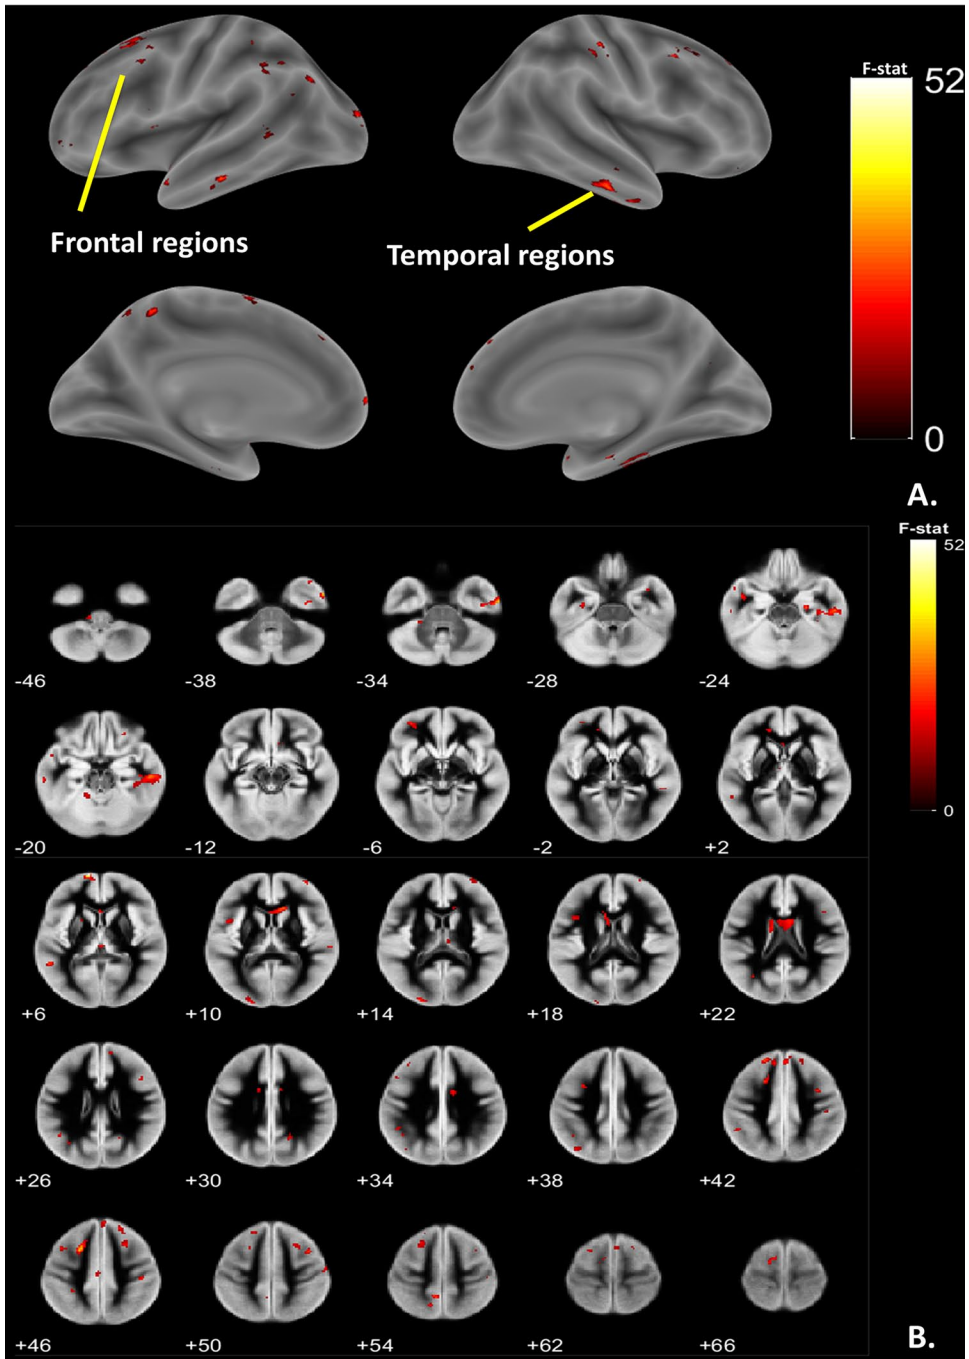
Neural underpinnings of pretask resting-state absolute alpha power through electroencephalography informing situational awareness-task-based functional magnetic resonance imaging as shown in (a) surface rendered view and (b) slice montage view. The activations are represented at uncorrected $p < .001$.
